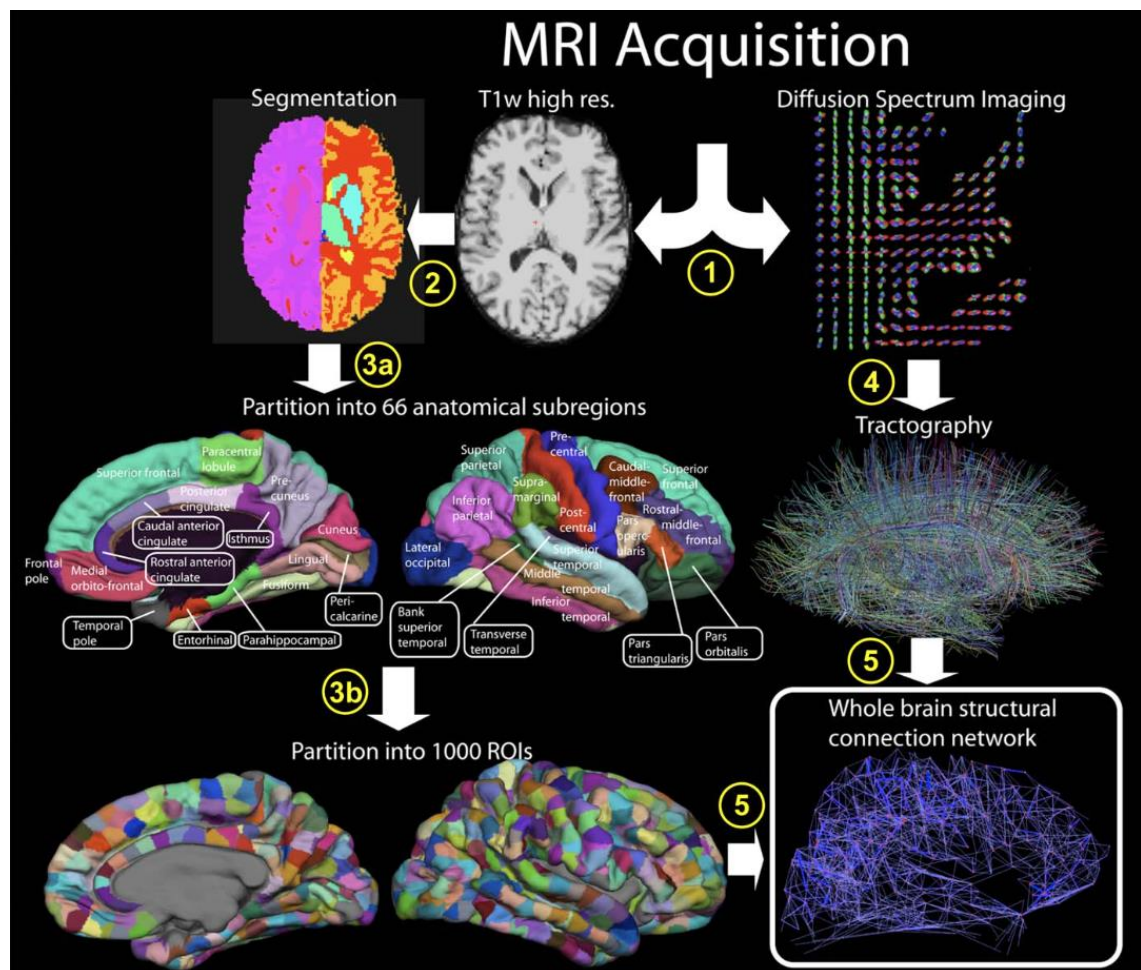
Acquisition procedure of DTI. MRI images are segmented into parcels comprising 66 and 1000 ROIs. Neuronal fibers are extracted using tractography (adapted from Hagmann et al., 2008).
